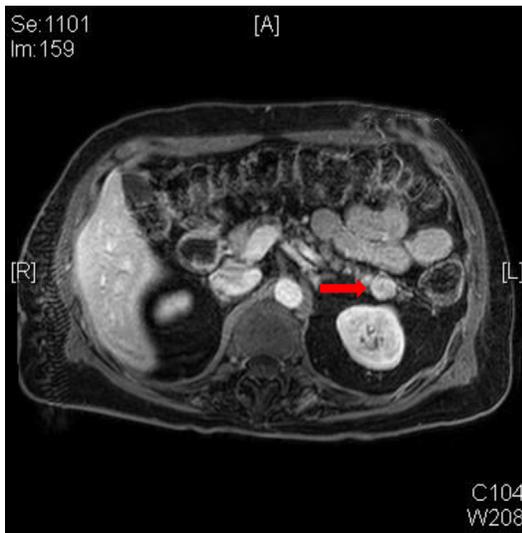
MRI demonstrates a 2-cm enhancing mass in the pancreatic tail (*arrow*). Resection confirmed PNET.
